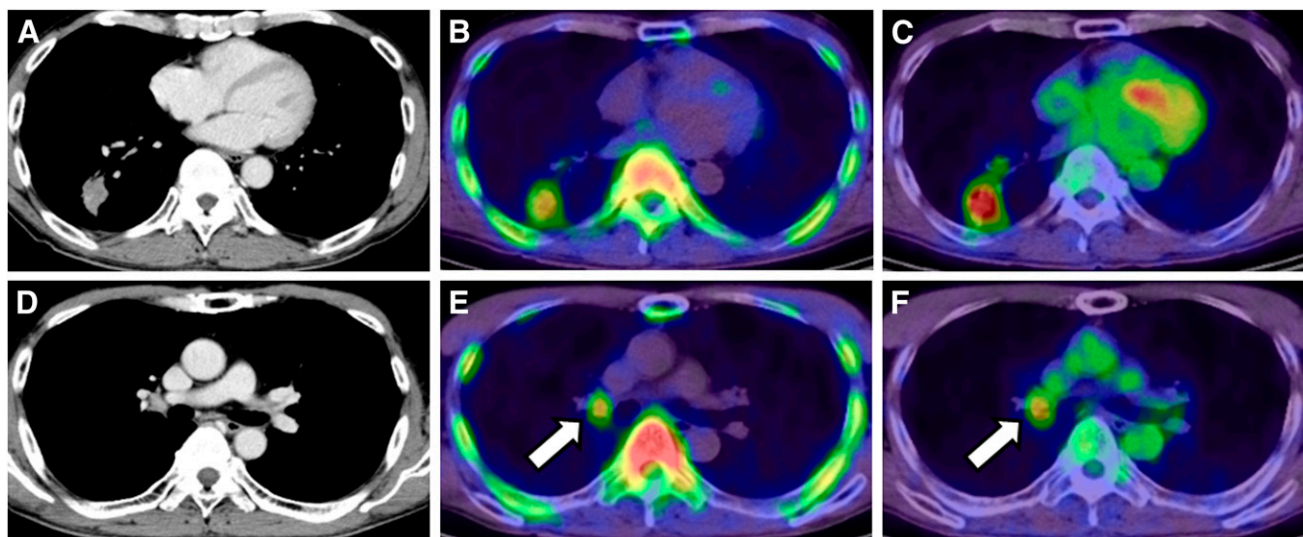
Axial images of CT (A), ^{11}C -4DST PET (B), and ^{18}F -FDG PET (C) in patient 9 with lung adenocarcinoma in right lower lobe. Right hilar lymph node metastasis is confirmed on CT (D), and uptake on both ^{11}C -4DST PET (E) and ^{18}F -FDG PET (F) identifies lesion (arrow). However, ^{11}C -4DST image is clearer than ^{18}F -FDG image because of low physiologic ^{11}C -4DST in mediastinum as blood pool.
